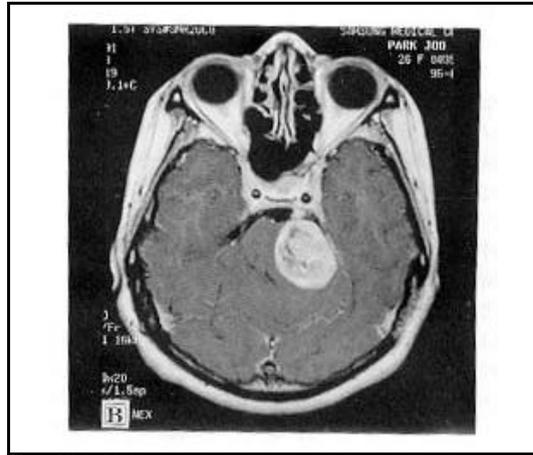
(b). MRI scan with contrast 5 months following FSRT using. The tumor is unchanged in size, but exhibits central necrosis.
